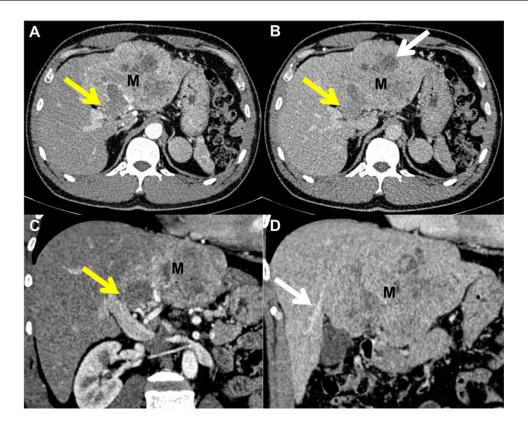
Contrast-enhanced CT scan revealed a large, necrotic HCC occupying the entire left liver lobe with invasion into the left portal vein. Axial (A, B) and coronal (C, D) reconstructions depicted the arterial phase (A, C) and portal venous phase (B, D). The mass (M) demonstrated characteristic features of HCC, including arterial phase hyperenhancement and washout, consistent with LI-RADS 5. Tumor invasion was evident within the entire left portal venous system (yellow arrow, A-C), sparing the right and main portal veins. Despite its size, the tumor remained confined to the left liver lobe, displacing the middle hepatic vein towards the right (white arrow, D). Areas of necrosis within the tumor were apparent as nonenhancing hypodense regions (white arrow, B). Additionally, a structure adjacent to the left adrenal gland, presumed to be residual splenic tissue from a prior splenectomy, was visible (A, B) and remained stable in postoperative imaging, ruling out metastasis.
